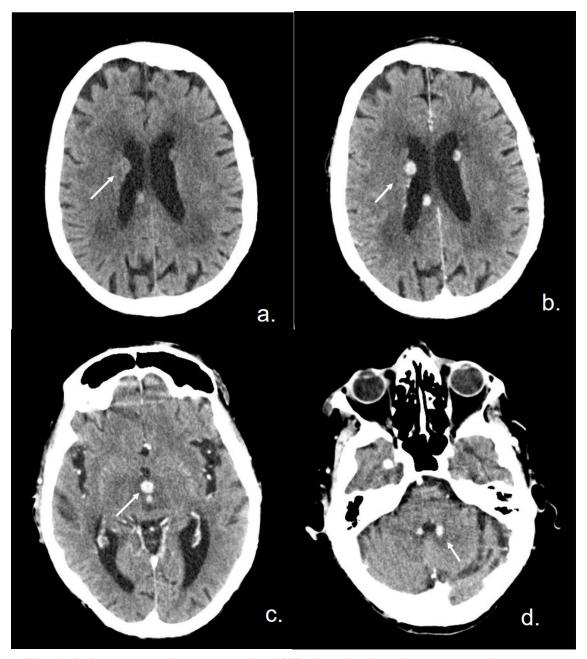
Axia computed tomography (CT) basal (a) and contrast-enhanced (b,c,d): demonstrating hyperdense lesions in the parenchyma around the lateral ventricle, third ventricle, and fourth ventricle, contrast-enhanced image demonstrated enhancement.
